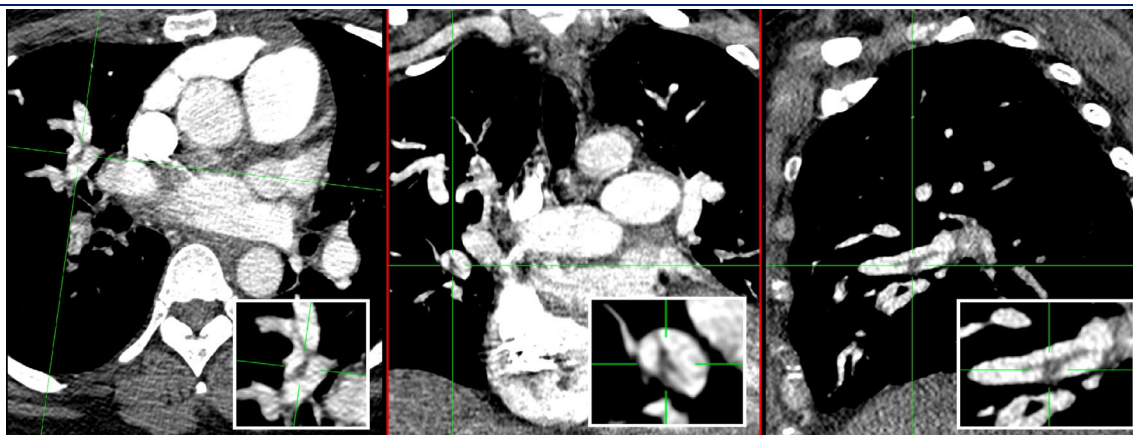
CT imaging focused on right middle lobe PE.
